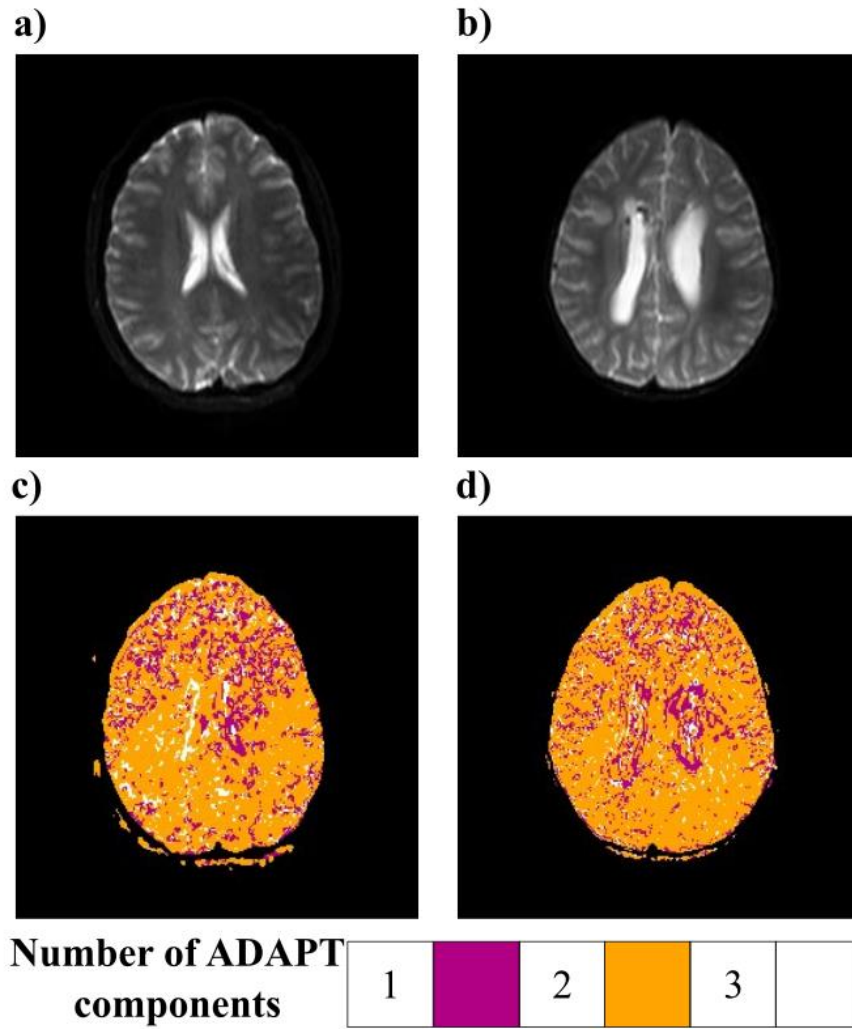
Example case of the ADAPT method applied to In-Vivo DWI axial slices. a) DWI slice of a volunteer where  $b$  value=0  $s/mm^2$ . b) DWI slice of patient with enlarged ventricles where  $b$  value=0  $s/mm^2$  c) ADAPT applied to volunteer slice and the corresponding number of detected components are displayed. f) ADAPT applied to patient slice.
